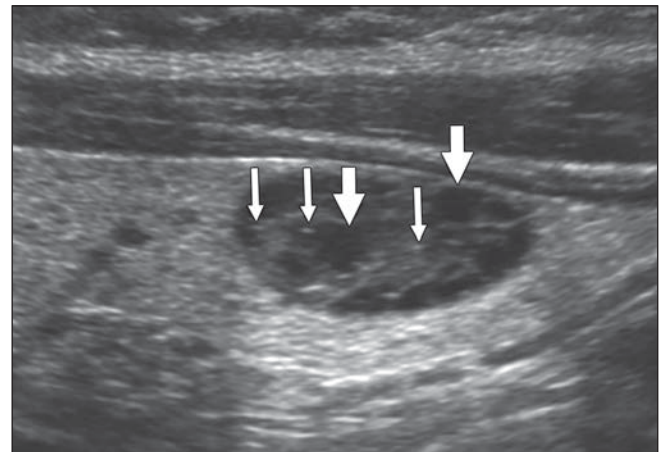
Transverse ultrasound image in 78-year-old man showing isoechoic, mixed cystic-solid lesion with category of TR2 (2 points). Posterior acoustic enhancement could be missed and cystic regions (thick arrows) misinterpreted as hypoechoic components of heterogeneous solid nodule (TR4, 4 points). In addition, back wall of cysts (thin arrows) could be misinterpreted as punctate echogenic foci, which would result in categorization of nodule as TR5 (5 points) and biopsy with 1.0-cm threshold instead of no biopsy at any size.
